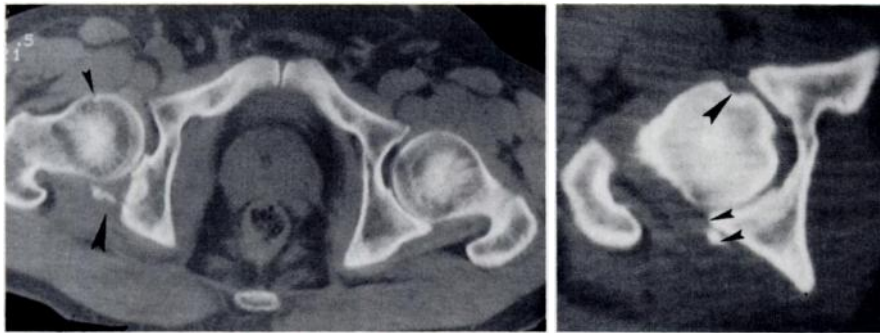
CT scan shows postreduction image after posterior dislocation of right hip, as evidenced by disruption of posterior pillar of acetabulum (*large arrowhead*). Note focal defect on anterior cortex of right femoral head (*small arrowhead*). Normal left femoral head shows no similar defect.
